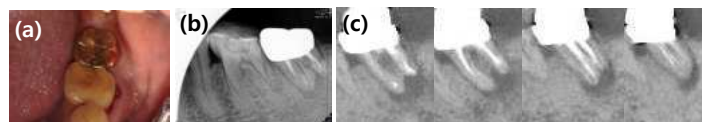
(a) initial intra-oral photograph (b) initial periapical radiograph (c) initial cone-beam computed tomography
